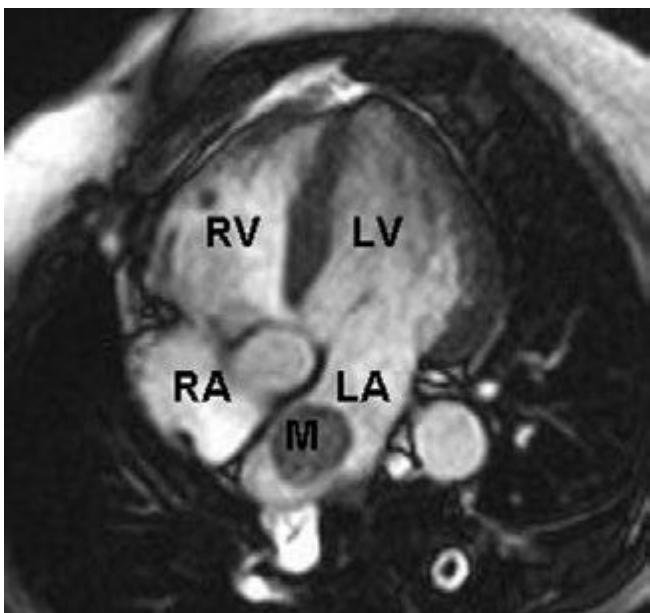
2 Cardiac magnetic resonance imaging demonstrating a rounded mass (M) within the left atrium (LA). Pathologic evaluation at the time of surgery revealed it to be an atrial myxoma. LV, left ventricle; RA, right atrium; RV, right ventricle.
